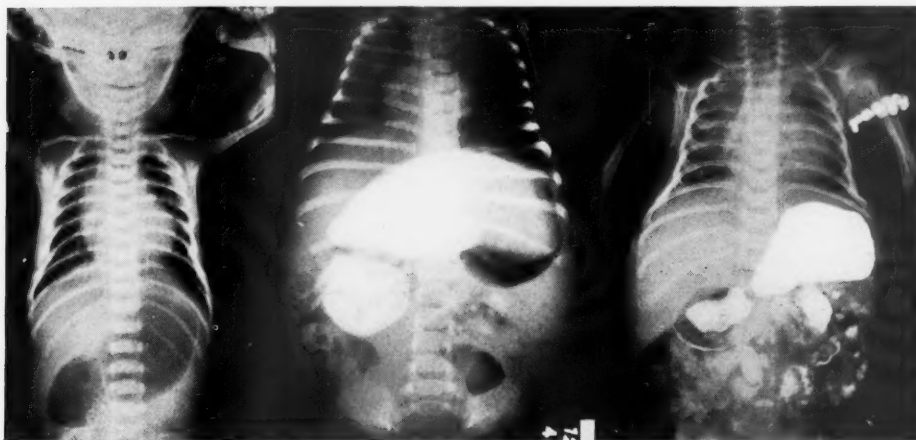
May 1, 1938: Roentgenogram taken three days after birth shows an abnormal distention of the stomach and duodenum with air.
